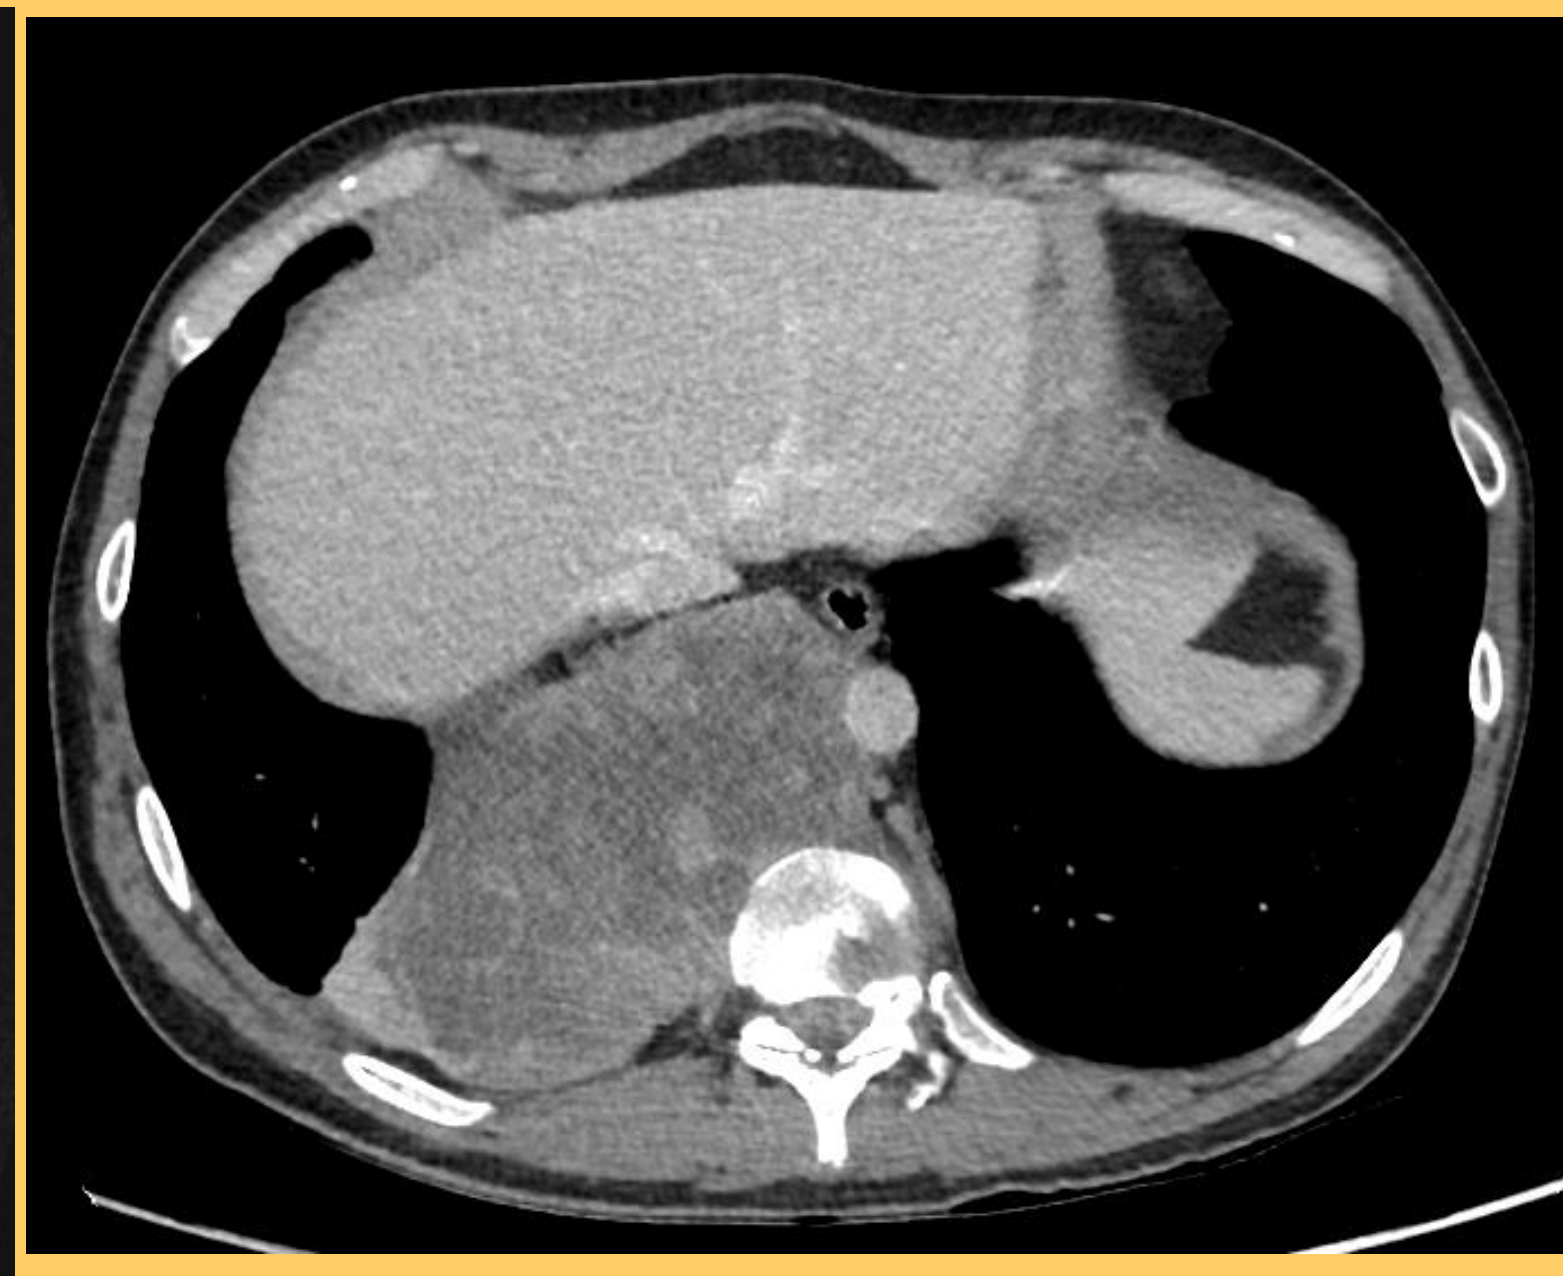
CT CAP September 2020
